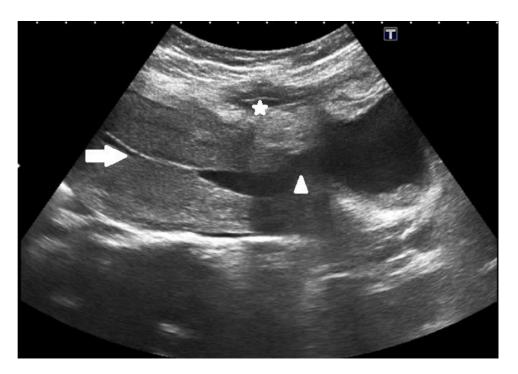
Gray-Scale Transabdominal Ultrasound Image. Post void image shows emptying of endometrial canal. Collapse of the fluid collection in anterior abdominal wall (star) also noted. Fistulous communication (arrow head) of uterus and urinary bladder remonstrated.
